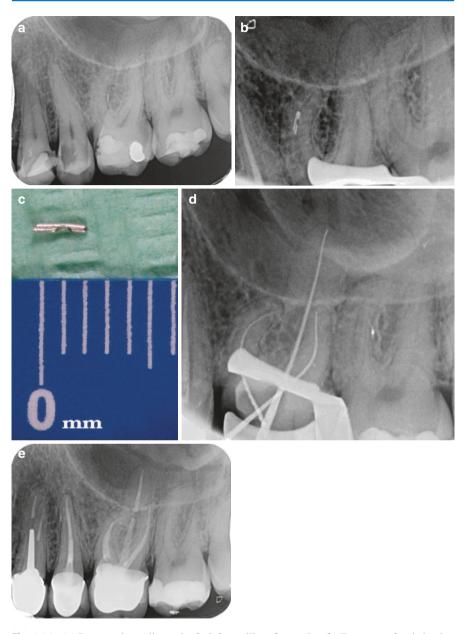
(a) Preoperative radiograph of a left maxillary first molar. (b) Fragment of an irrigation needle in the mesiobuccal canal. (c) Removal of the fragment. (d) Working length determination radiograph. (e) Radiograph appearance after the completion of the RCT and the rehabilitation of the tooth (Courtesy of Dr. P. Mourouzis)
